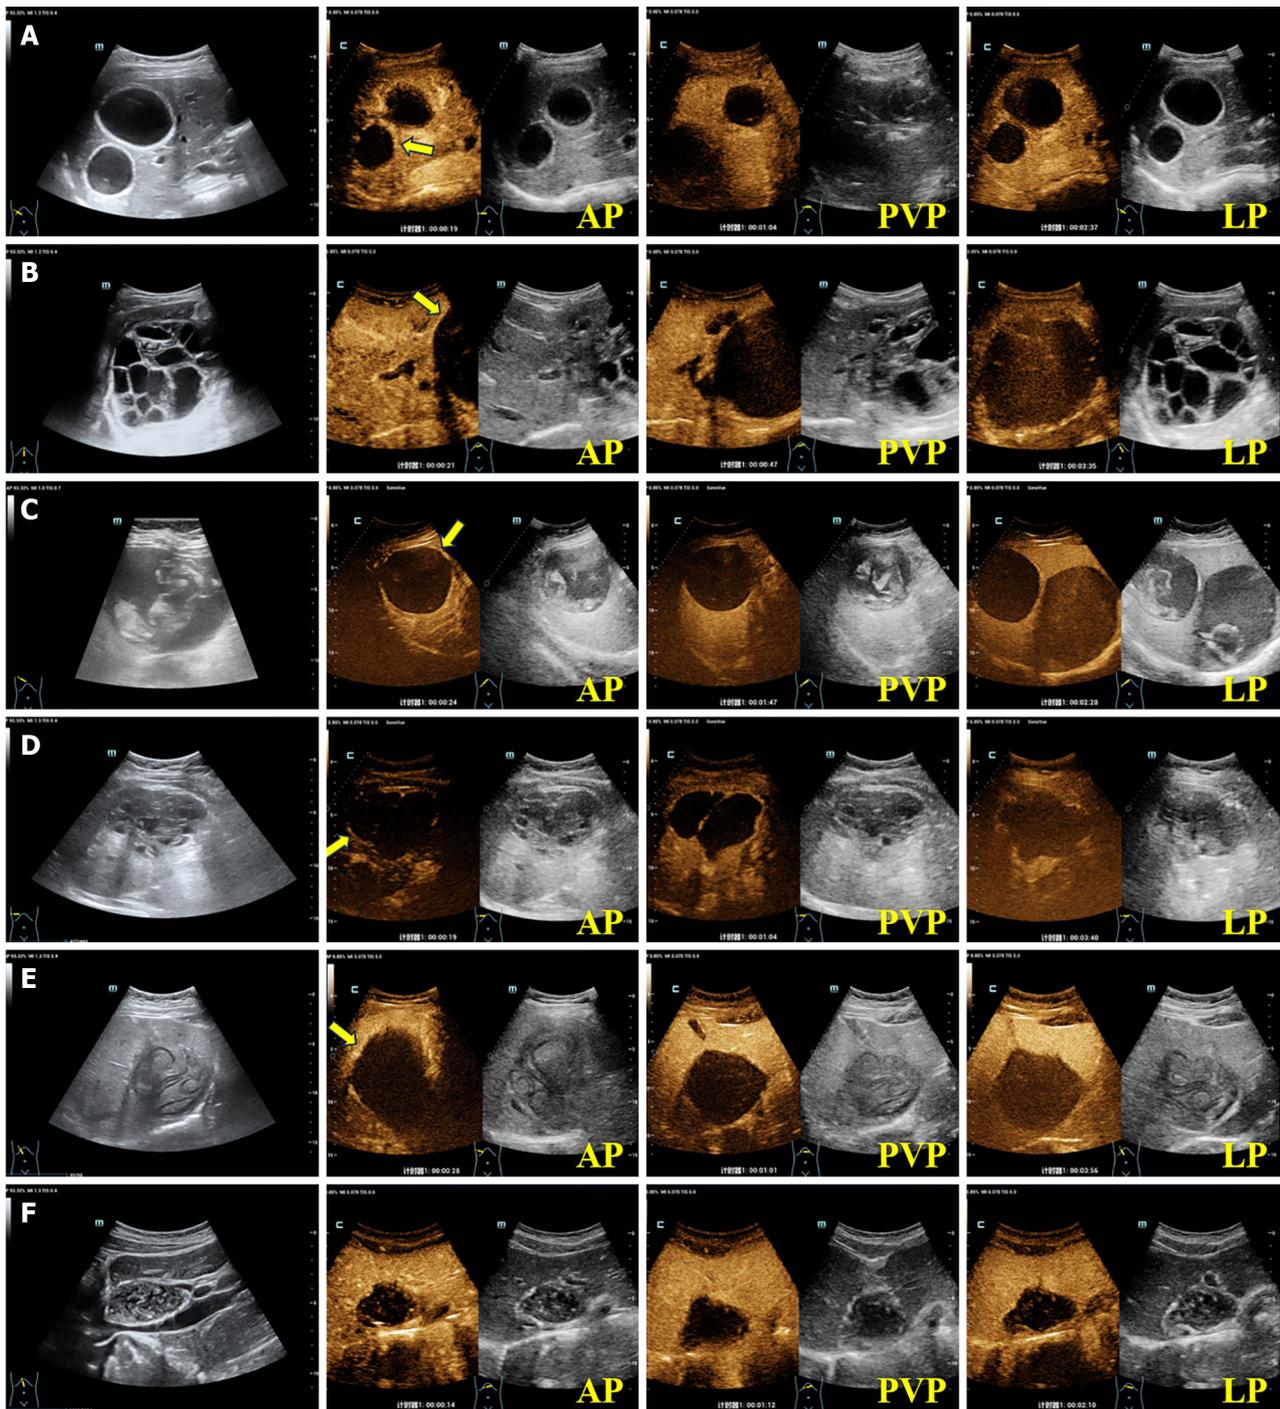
Contrast-enhanced ultrasound images of hepatic cystic echinococcosis. A: A 27-year-old female patient presenting with a liver lesion of hepatic cystic echinococcosis 1 (HCE1), exhibiting peripheral "rim-like" enhancement in the arterial phase (AP) on contrast-enhanced ultrasound (CEUS) (the yellow arrow), with no internal enhancement observed; B: A 41-year-old female patient presenting with a liver lesion of HCE2, exhibiting slightly peripheral "rim-like" enhancement in the AP on CEUS (the yellow arrow), with no internal enhancement detected; C: A 56-year-old female patient presenting with a liver lesion of HCE3a, exhibiting slightly peripheral "rim-like" enhancement in the AP on CEUS (the yellow arrow), with no internal enhancement observed; D: A 49-year-old male patient presenting with a liver lesion of HCE3b, exhibiting slightly peripheral "rim-like" enhancement in the AP on CEUS (the yellow arrow), with internal septal enhancement visible; E: A 47-year-old female patient presenting with a liver lesion of HCE4, exhibiting slightly peripheral "rim-like" enhancement in the AP on CEUS (the yellow arrow), with no internal enhancement observed; F: A 29-year-old female patient presenting with a liver lesion of HCE5, with no obvious enhancement in the AP, portal venous phase, or late phase.
